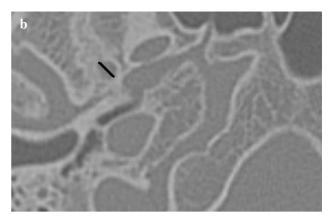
a, b. (a) On axial CT image, foramen ovale and foramen spinosum are seen (FO, FS). (b) The FS is measured at its greatest diameter (line)
